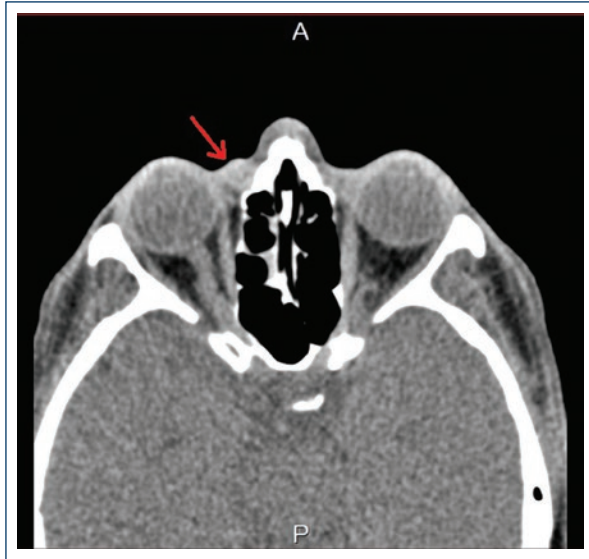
Orbital computed tomography showing a 6 mm diameter cystic lesion in the medial supracanthal area with a 114 Hounsfield unit density (arrow).
